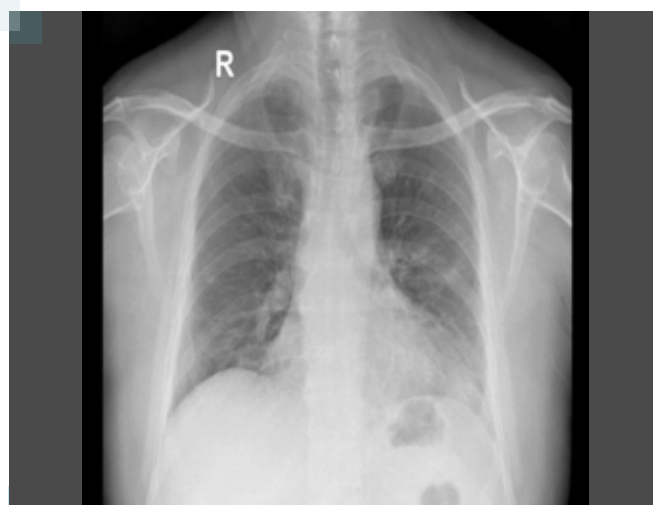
b : Chest x-ray on follow up visit after 4 weeks
